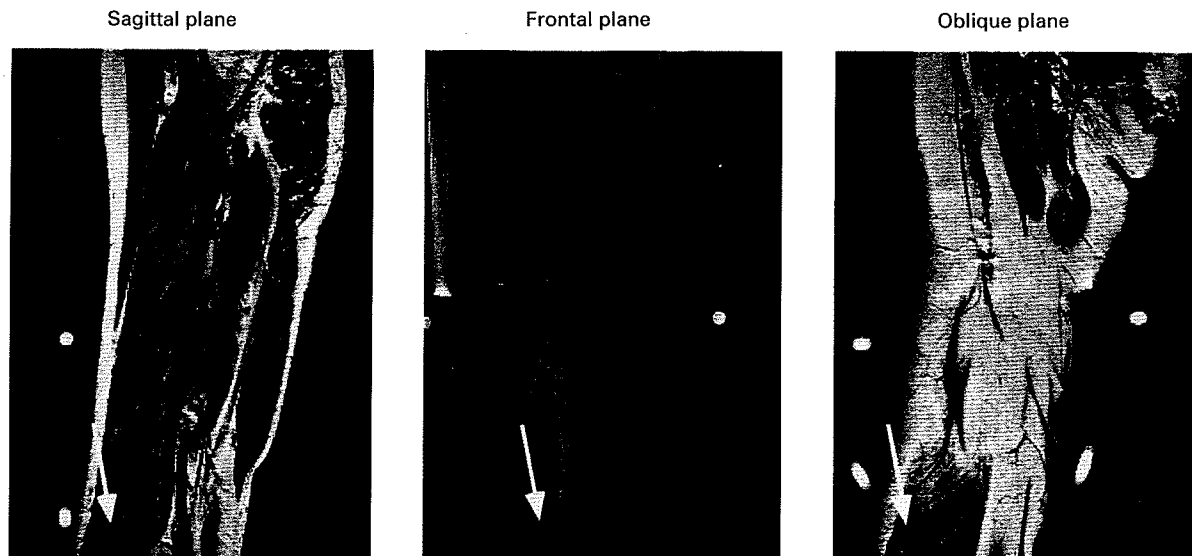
Longitudinal MR images in the sagittal, frontal and an oblique plane (45° from frontal). The arrows identify a single point where a striation pattern is visible in all 3 planes.
